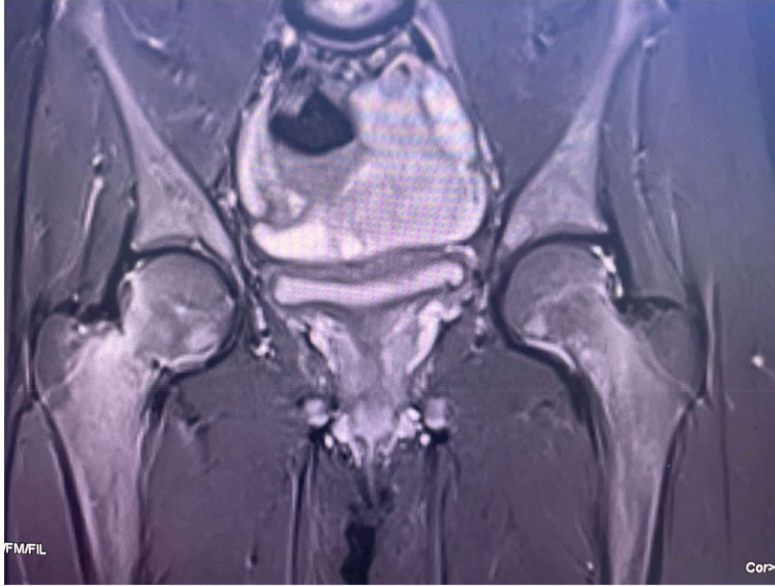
MRI PELVIS SHOWING INCOMPLETE UNDISPLACED FRACTURE LINES AT LATERAL AND MEDIAL ASPECT OF RIGHT FEMORAL NECK AND MEDIAL ASPECT OF LEFT FEMORAL NECK.
